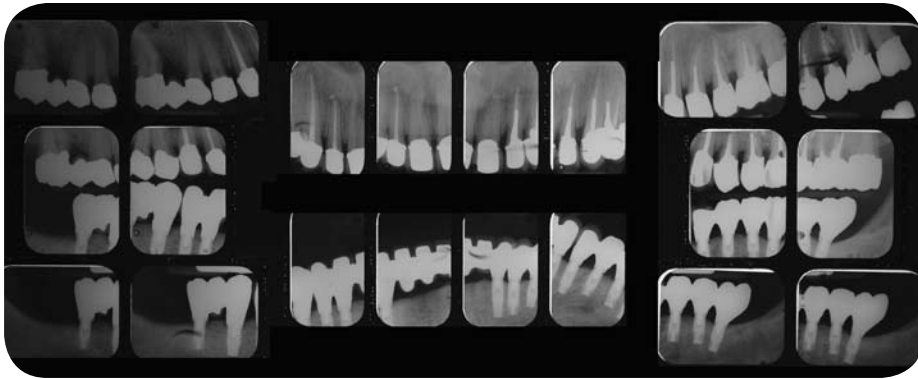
Full-mouth radiographs and photograph of definitive restorations.
